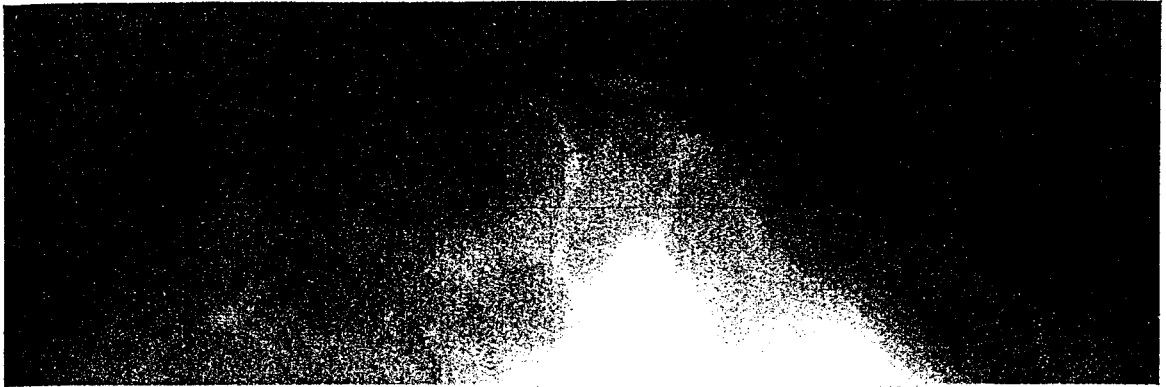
(a) Right breast, x-ray image.
